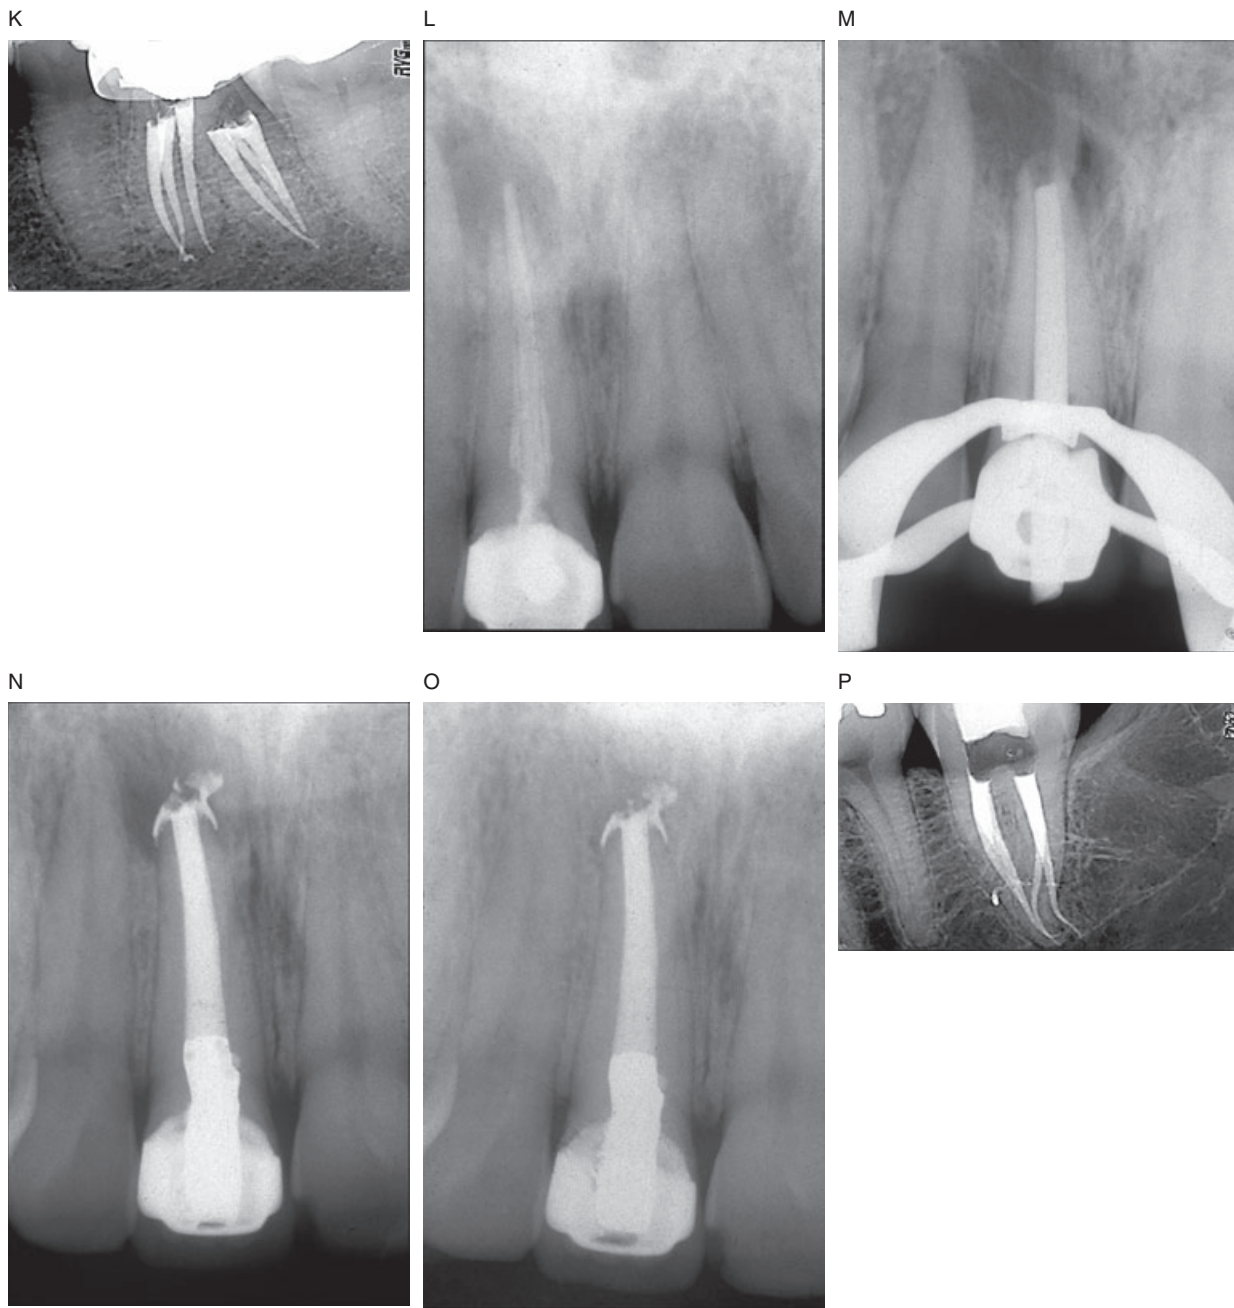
cont'd L, Mechanical objective number 5 states to keep the foramen as small as is practical. Pretreatment film shows presence of a periradicular radiolucency. M, If there is enough tooth structure to make a continuously tapering shape, an appropriate cone-fit is possible. N, Posttreatment. O, 9-month healing. P, Radiographic evidence of achieving all five mechanical objectives (courtesy of Dr. Jason West).
